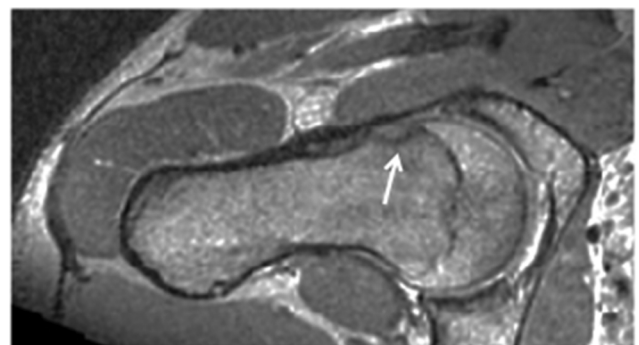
Hip joint with cam morphology (α -angle $\geq 55^\circ$). Note: MRI examination of a male skier showing cam morphology with an α -angel above $>55^\circ$ (arrow).
